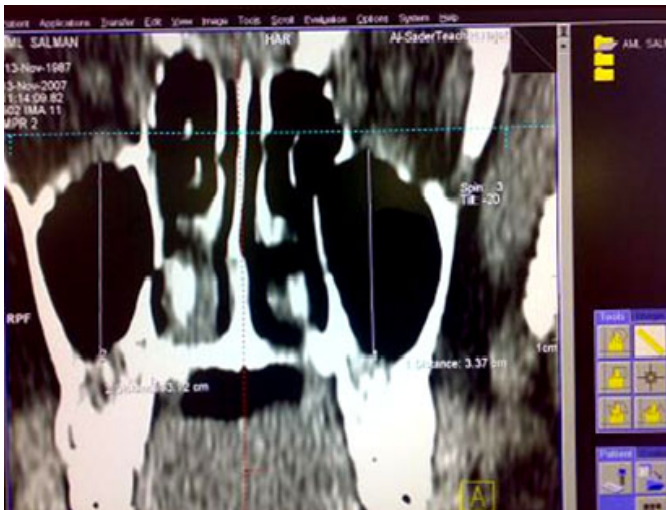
The height of the maxillary sinus measured from the reconstructed coronal CT sections.
